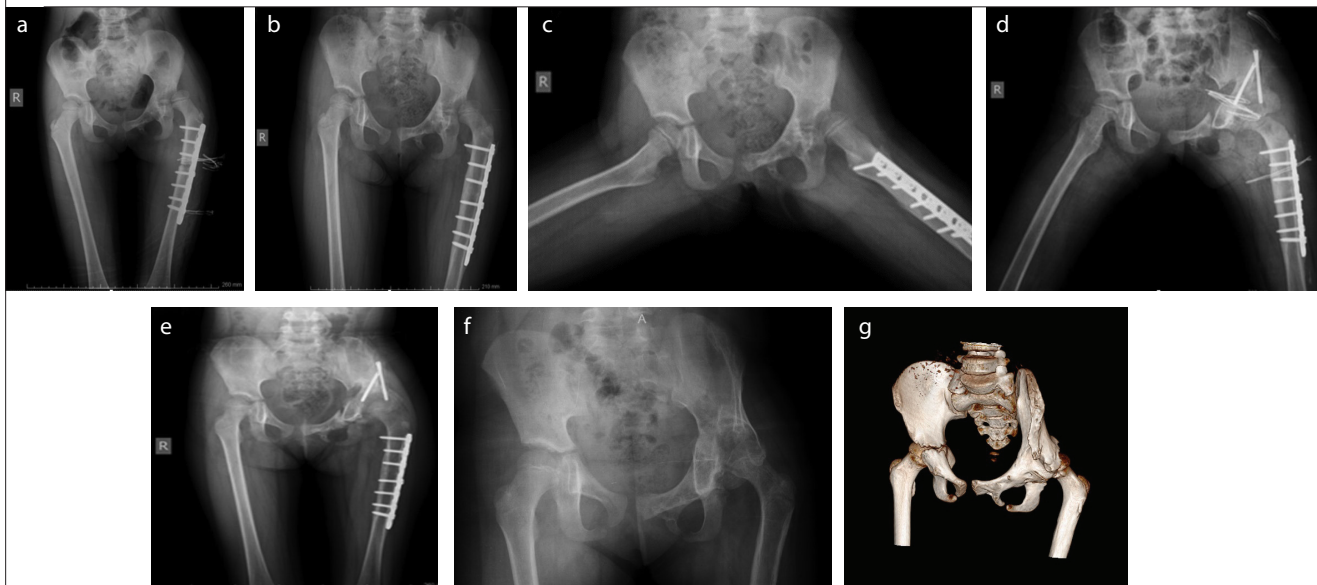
a-g. Postoperative plain radiographic images. (a) AP radiography of the left femur after correction of malunion (postoperative 1<sup>st</sup> day). (b) AP radiography of the left femur after correction of malunion (postoperative 6<sup>th</sup> month). (c) Lateral radiography of the left femur after correction of malunion (postoperative 6<sup>th</sup> month). (d) AP radiography of the left femur and pelvis after acetabular osteotomy (postoperative 1<sup>st</sup> day). (e) AP radiography of the left femur and pelvis after acetabular osteotomy (postoperative 3<sup>rd</sup> month). (f) AP radiography of the left femur and pelvis after acetabular osteotomy (postoperative 2<sup>nd</sup> year). (g) Three-dimensional pelvic computed tomography scan. (postoperative 2<sup>nd</sup> year)
